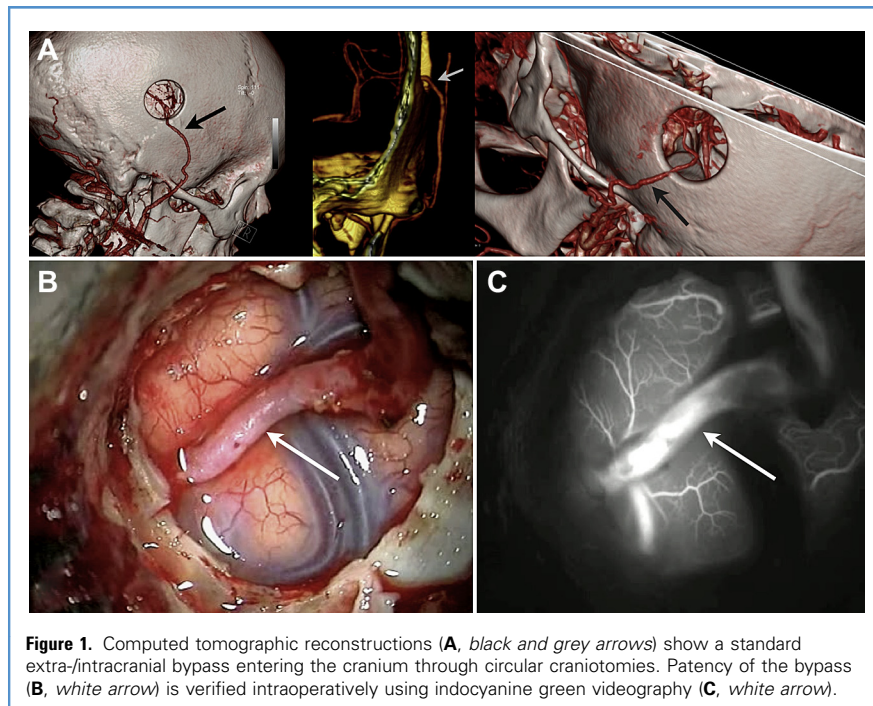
Computed tomographic reconstructions (A, black and grey arrows) show a standard extra-intracranial bypass entering the cranium through circular craniotomies. Patency of the bypass (B, white arrow) is verified intraoperatively using indocyanine green videography (C, white arrow).
